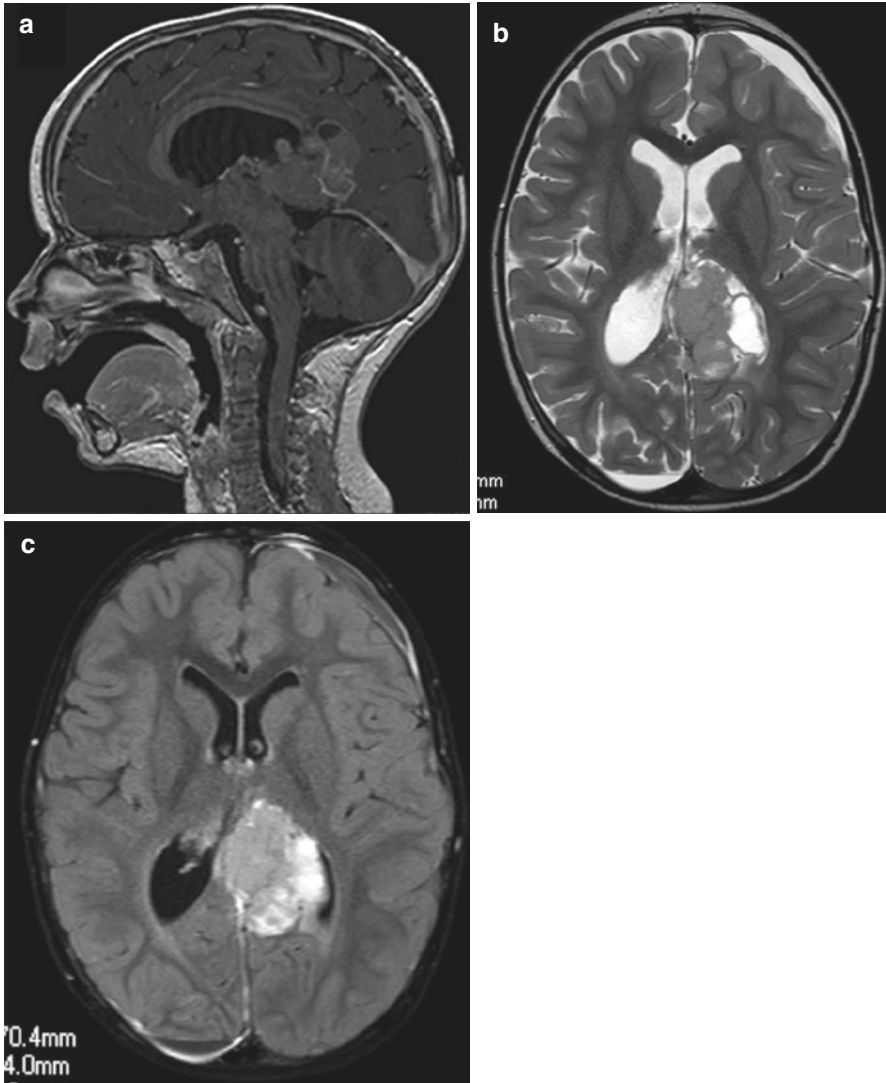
PTPR in T1WI with contrast (a), T2WI (b), and FLAIR (c) MRI sequences
